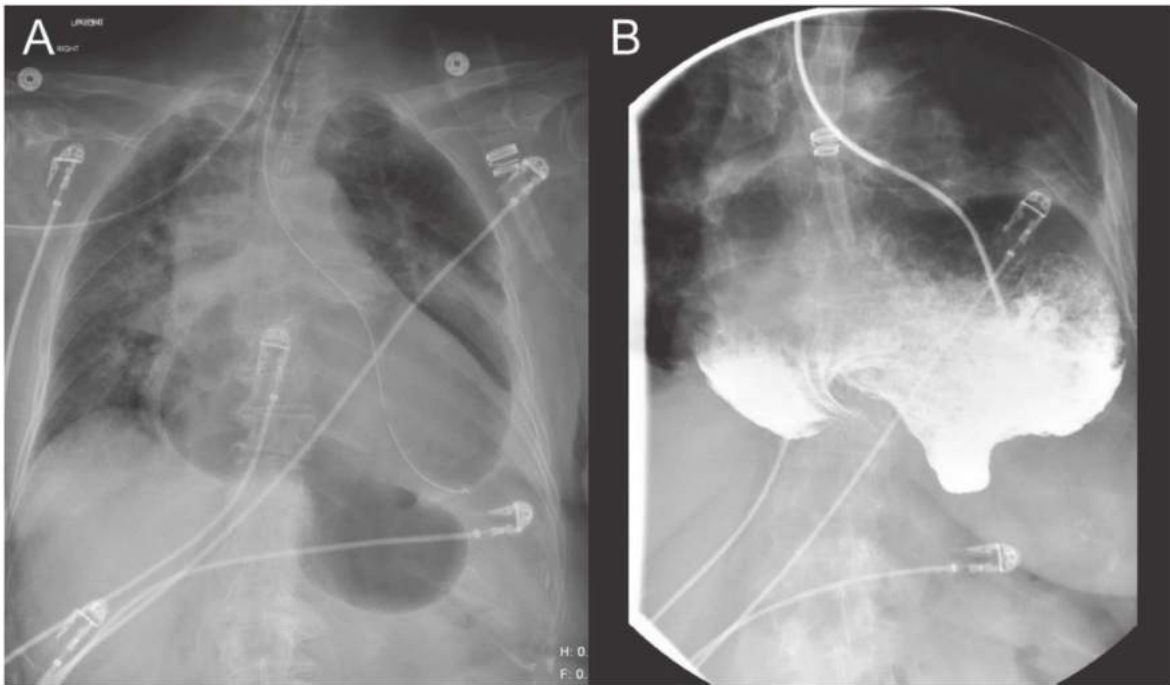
• A, Chest x-ray and (B) barium esophagram showing an incarcerated type III hiatal hernia with complete obstruction requiring emergent repair.
